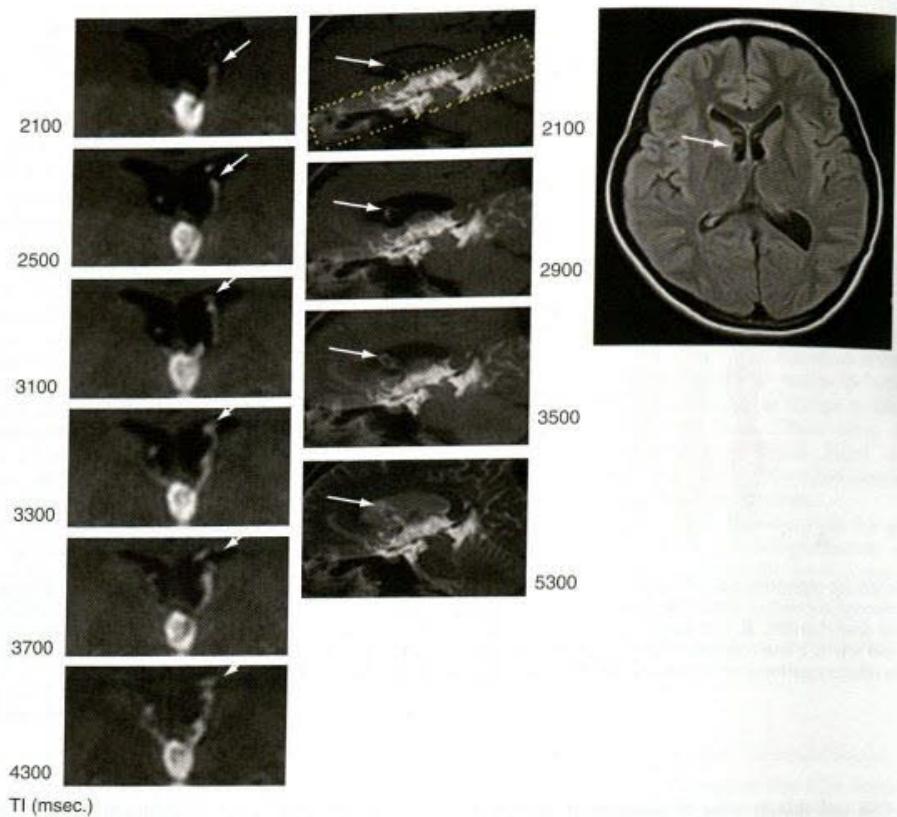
Left, Series of time-dependent coronal images acquired after a labeling pulse was placed on the third ventricle. Middle, Series of time-dependent sagittal oblique images acquired after a labeling pulse was placed on the third ventricle. The high signal intensity (yellow arrows) on these coronal and sagittal oblique images indicates turbulent CSF reflux flow from third ventricle into the lateral ventricles through the foramen of Monro. Right, This turbulent flow is frequently seen as a CSF flow artifact (arrow) on axial fluid-attenuated inversion recovery (FLAIR) images.
